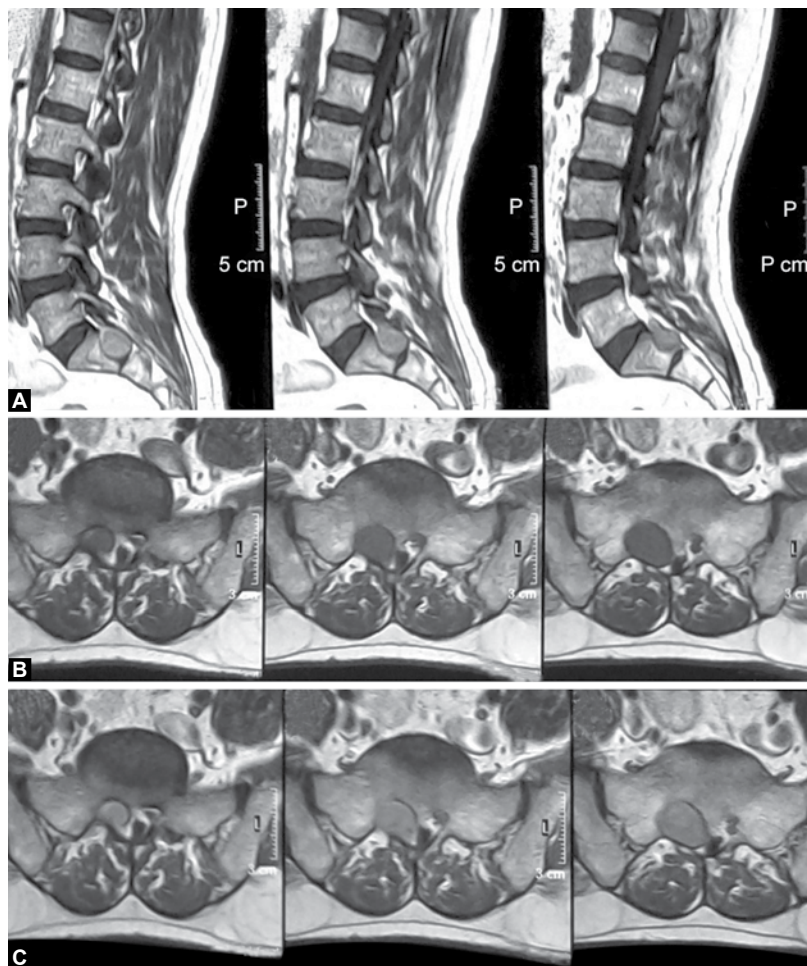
to C: Meningioma (A) T1-weighted sagittal MR image shows homogenous high signal intensity mass: (A) The tumor is located at the D1-D2 level. (B and C) T1 and T2-weighted coronal MR image shows a space occupying mass compressing the spinal cord
